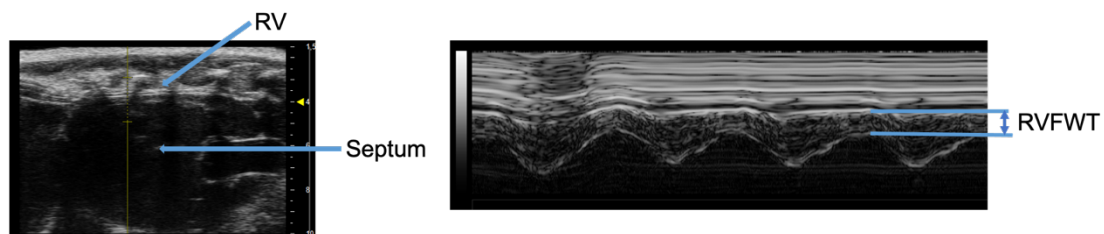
The view of parasternal long-axis of RV outflow tract and measurement of right ventricular free wall thickness (RVFWT).
